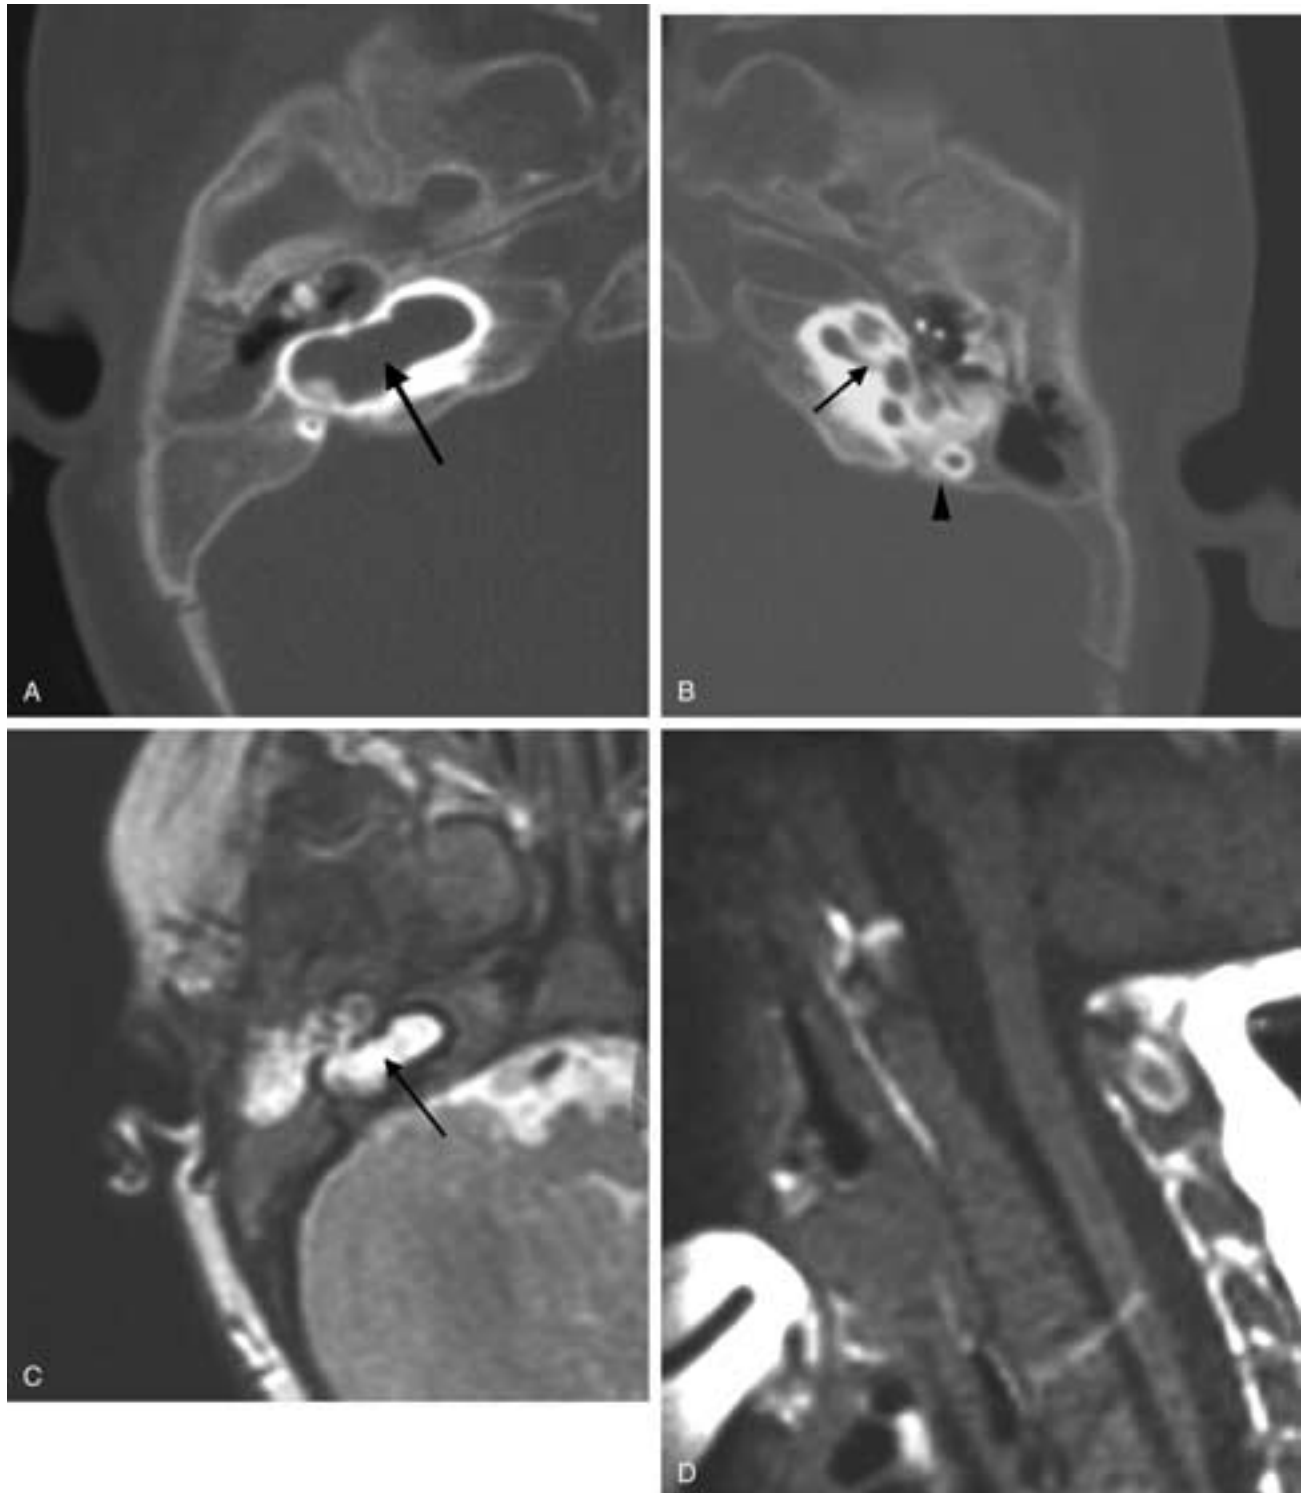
Klippel-Feil syndrome/common cavity. A, Axial CT image showing no distinct cochlea, vestibule, or semicircular canals and large common cavity (*black arrow*) on the right. B, Axial CT image of normal inner structures on the left: normal cochlea (*black arrow*) and normal posterior semicircular canal (*black arrowhead*). C, Axial T2-weighted MR image showing the fluid signal intensity in the common cavity (*black arrow*). D, Sagittal T1-weighted MR image showing fusion of multiple cervical vertebral bodies.
